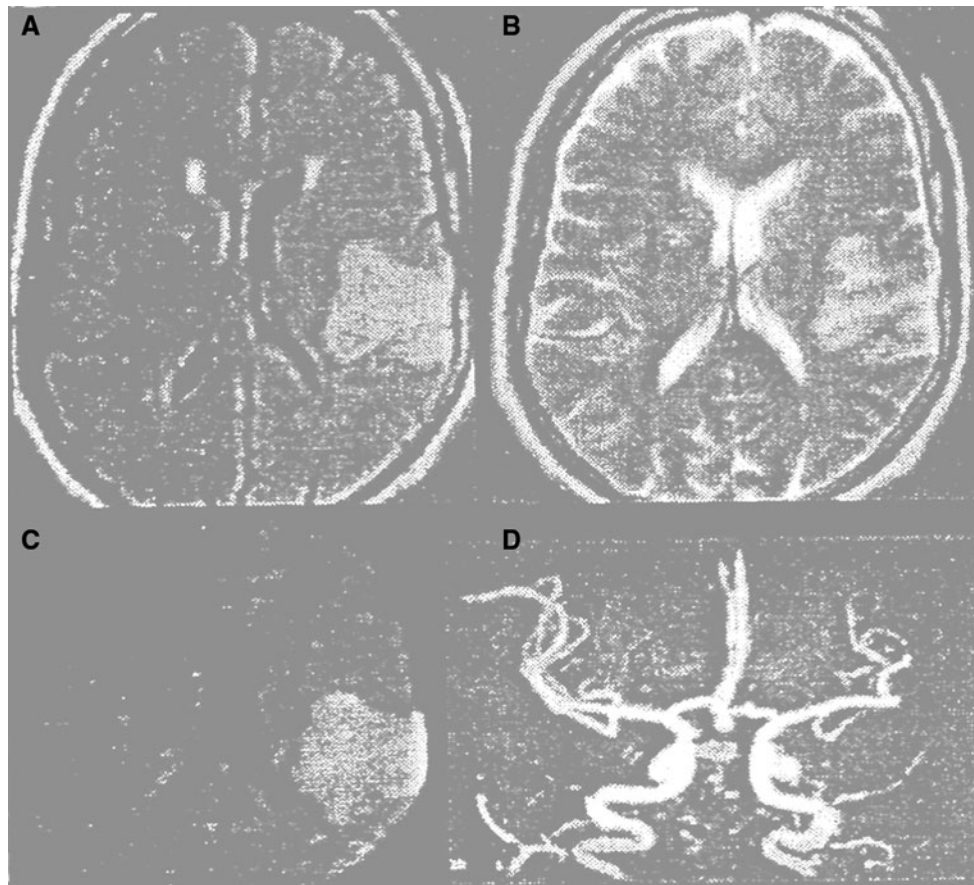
FLAIR (a), T2WI (b), DWI (c) and MRA (d) images of a 36-year-old female with SLE of 2-year duration: She developed acute right-sided hemiplegia (CVS). Her MRI showed left hyperintense
